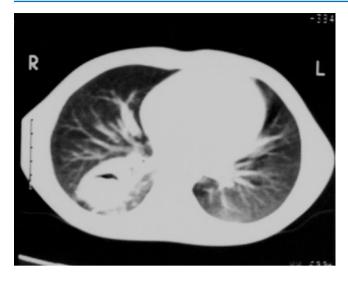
CT thorax showing pulmonary sequestration
